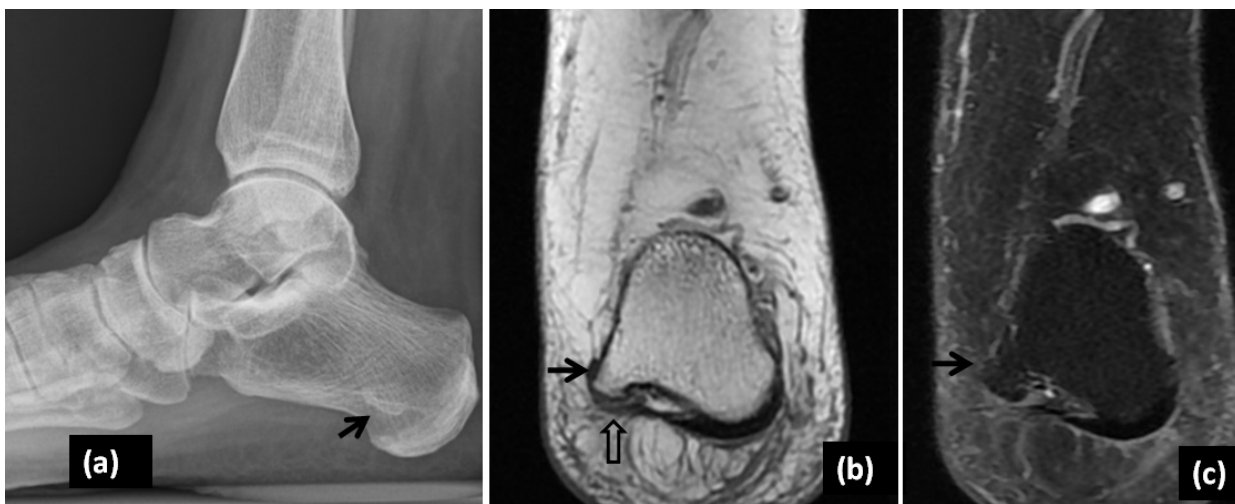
A 49-year-old female patient being investigated for medial sided right ankle pain presents with incidental finding of hypertrophic lateral plantar process of the calcaneal tuberosity (black arrows) on lateral ankle radiograph (a), coronal T1 (b) and STIR (c) MR images. Note that fibers of abductor digiti minimi originate from this bony prominence (open arrow).
